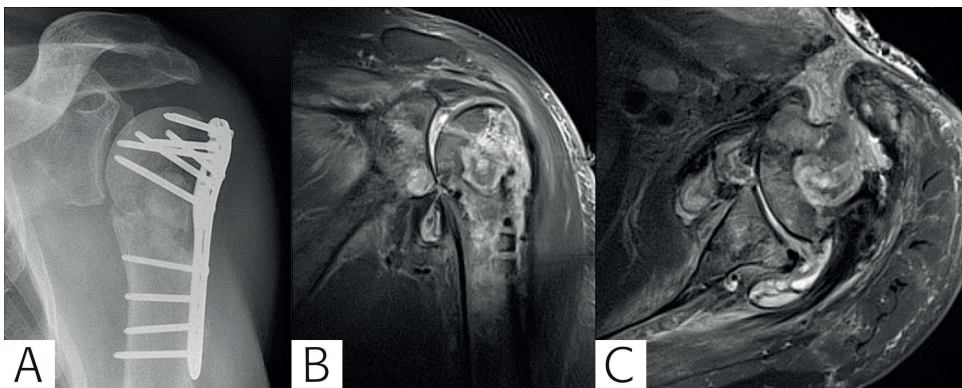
Example of an x-ray (A) and T2-STIR MRI images (B coronal view, C sagittal view) performed in an patient with an infected proximal humerus. The MRI demonstrated the extent of the infection with a skin defect, fluid/pus in the proximal humerus with surrounding oedema, a sinus tract and the involvement of the adjacent joint with possible involvement of the glenoid.
